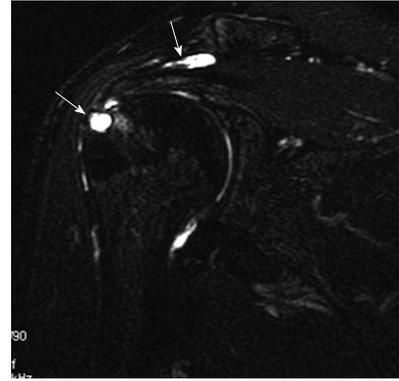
Bony degenerative changes. Coronal oblique fat-sat T2-weighted image showing focal fluid-like high signal within the distal supraspinatus tendon fibres reported as partial capsular surface tear with subcortical cystic erosion of the greater tuberosity at the rotator cuff insertion (thin arrow). Also note fluid signal within the subacromial subdeltoid bursa reported as bursitis (thick arrow).
